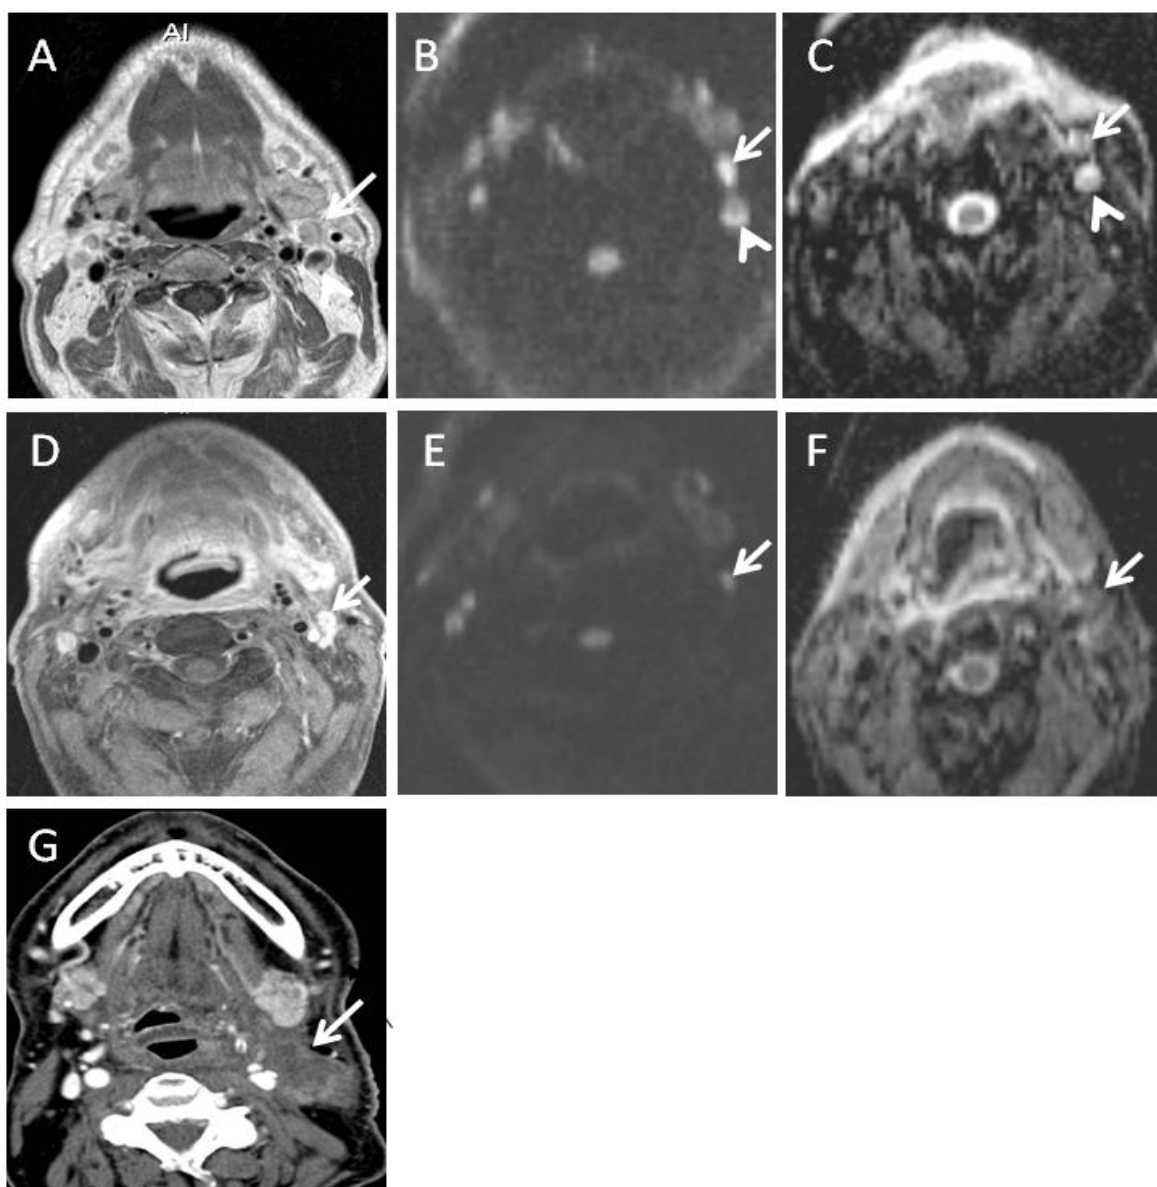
Patient with left tonsillar cancer shows two subcentimetre nodal metastases in left level 2 of the neck prior to treatment on (a) contrast-enhanced T1-weighted turbo-spin echo (TSE) MRI, (b) b1000 diffusion-weighted image and (c) ADC-map (arrow, arrowhead). At 4 weeks during chemoradiotherapy, (d) the posterior adenopathy has completely regressed (arrowhead), while the more anterior lymph node has partially regressed (arrow). (e) Persistent hyperintensity is present in the anterior lymph node correlating to (f) a ΔADC (in %) < 5, indicative of bad treatment response (arrows). (g) Follow-up CT scan shows nodal tumour recurrence at 8 months after completion of chemoradiotherapy (arrow).
